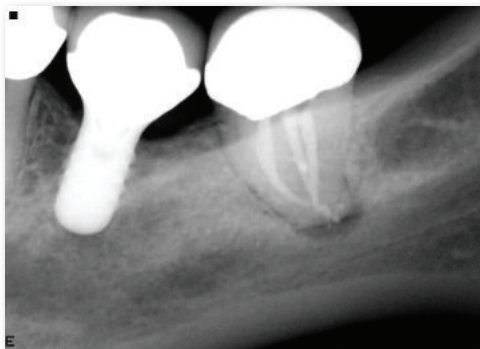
An immediate postoperative radiograph of the tooth following root canal therapy.
